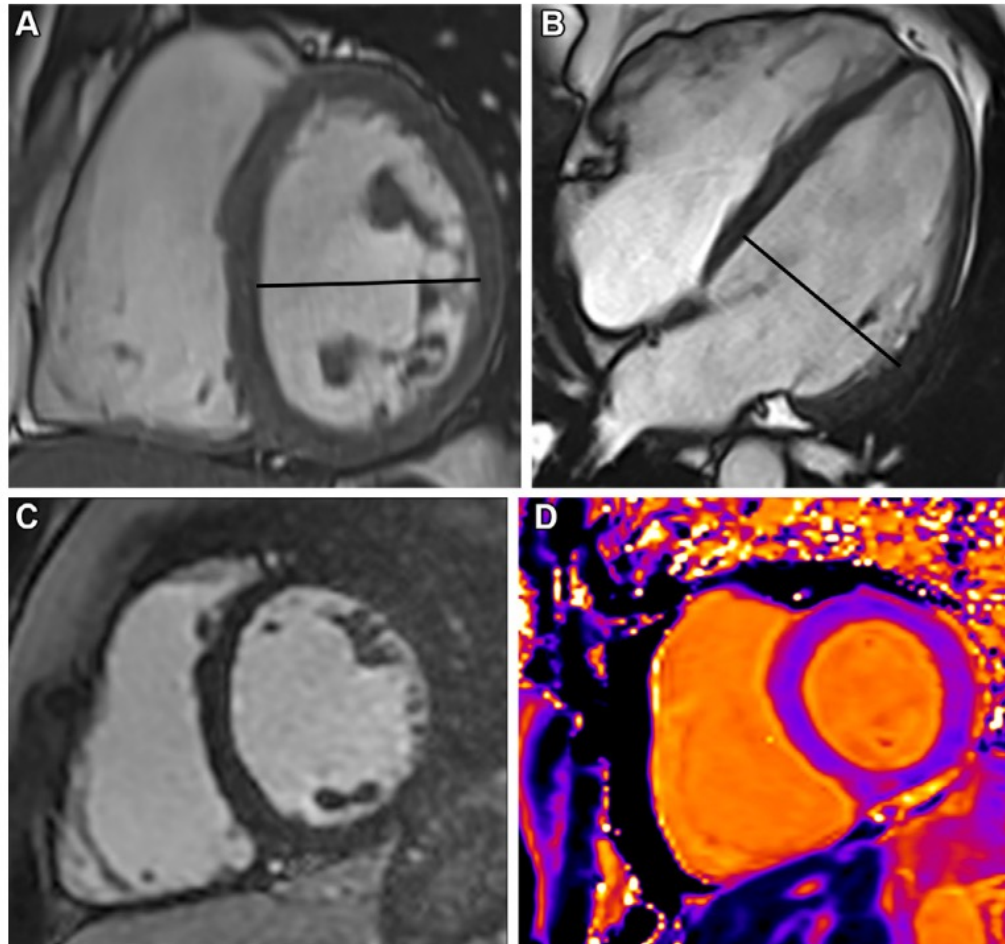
Athlete's heart (dilated phenotype) in a 45-year-old competitive dancer with a family history of SCD. MRI was performed during preparticipation screening. (A, B) Short-axis (A) and four-chamber (B) cine SSFP images show dilated LV with end-diastolic diameter of 60 mm and EDVi of 119 mL/m² (normal, <99 mL/m²). Ejection fraction was normal at 55%. The RV is also mildly dilated with EDVi of 111 mL/m² (normal, <105 mL/m²). (C) No abnormal LGE is seen on the short-axis delayed enhancement image. (D) Short-axis T1 map shows normal myocardial T1 values. This was diagnosed as athlete's heart.
